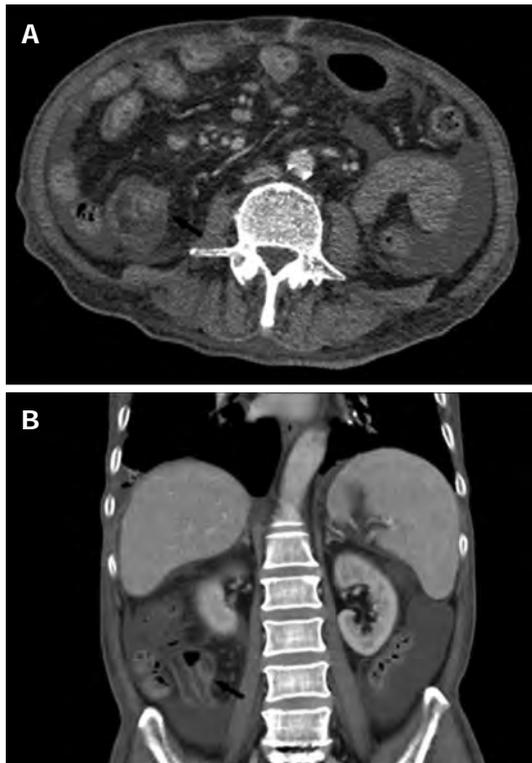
Abdominal computed tomography showed mild intestinal dilatation and wall thickening in the terminal ileum (marked with black arrow), and moderate ascites in the abdominal cavity. A: Horizontal slice; B: Coronal slice.
